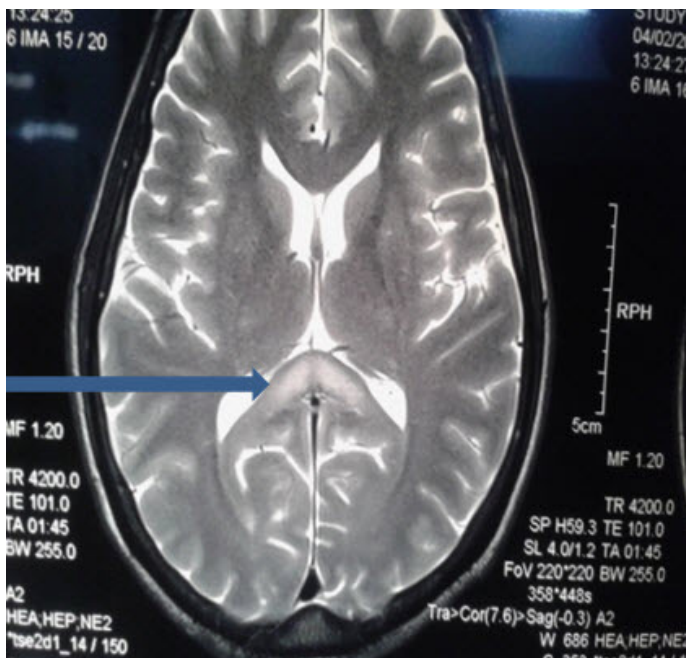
Hyperintensity of splenium of corpus callosum on T2-weighted image in MRI brain
